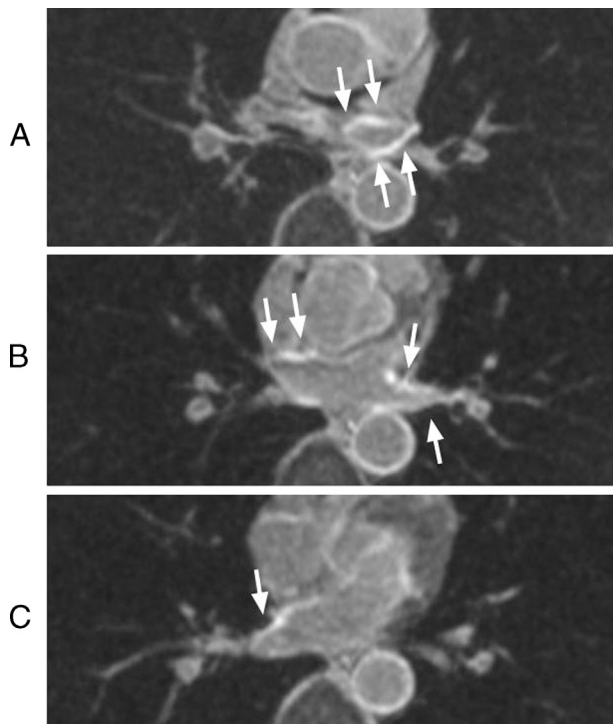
Transaxial images from delayed-enhancement magnetic resonance imaging at the level of A: the left superior pulmonary vein (PV), B: left inferior and right superior PV, and C: right inferior PV. The arrows show the site of delayed enhancement.
